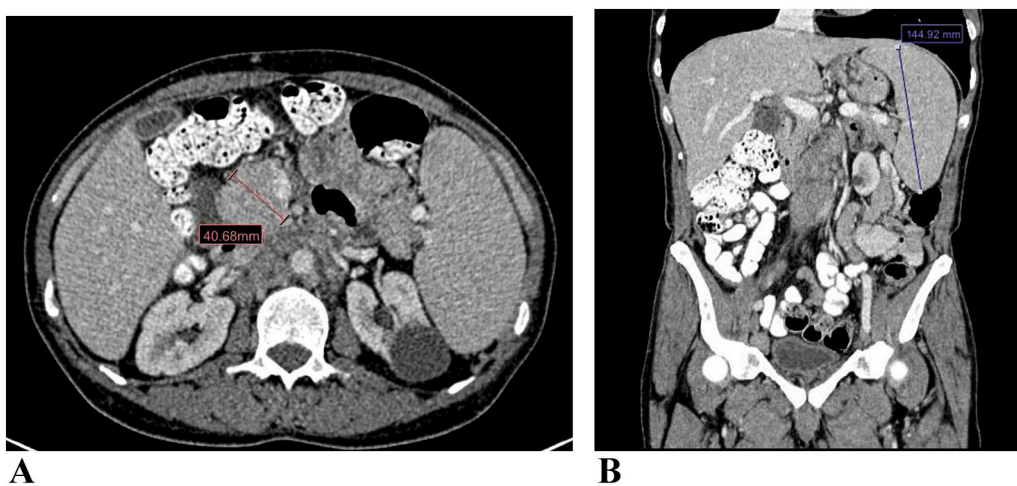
Whole body CT showing: A) pancreatomegaly (axial view); and, B) splenomegaly (coronal view) suggesting lymphomatoid infiltration.
